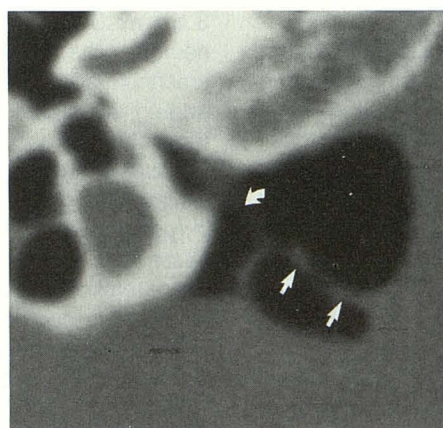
Case 13: Right air CT cisternogram shows vascular loop with its proximal limb superimposed on neurovascular bundle in cerebellopontine angle (straight arrows). Part of neurovascular bundle is also visible in inferior portion of internal auditory canal (curved arrow).
